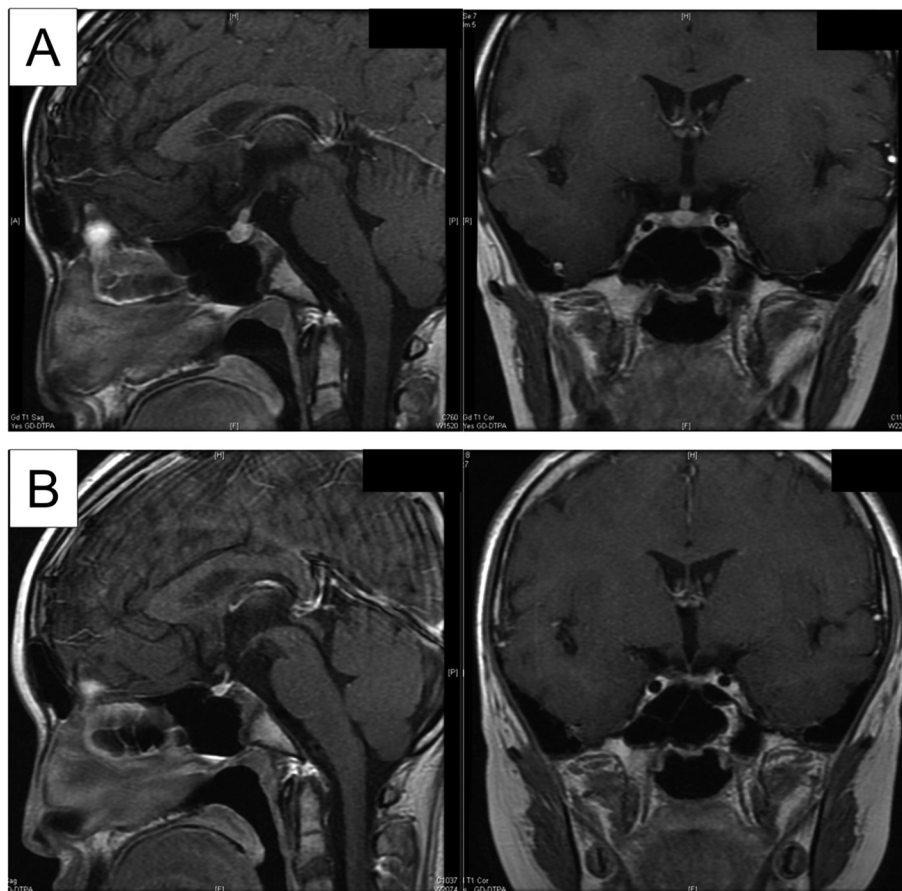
Contrast-enhanced T1-weighted magnetic resonance imaging. A: Before chemotherapy initiation, the pituitary gland and stalk were enlarged. No lesions were observed in the hypothalamus. B: During chemotherapy, the pituitary gland and stalk reduced in size. No newly developed lesions were observed in the hypothalamus.
